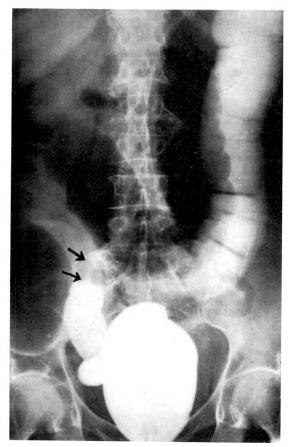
Case No. A1808. Seventy year old white female with a chief complaint of progressive constipation of 6 months' duration. Rapidly developing abdominal distention was present during the preceding 3 days. A barium enema study demonstrated complete obstruction at about the midsigmoid with no indication as to the cause or exact site of obstruction; however, the hypaque enema study shows filling of the rectum and distal sigmoid, demonstrating incomplete obstruction at about the mid-sigmoid colon. Note the napkin ring deformity. The caliber is reduced to 8 mm. in diameter through a segment approximately 3 cm. in length. The colon is dilated proximal to the site of the lesion. The roentgenologic diagnosis of annular carcinoma of the mid-sigmoid was confirmed at operation.
